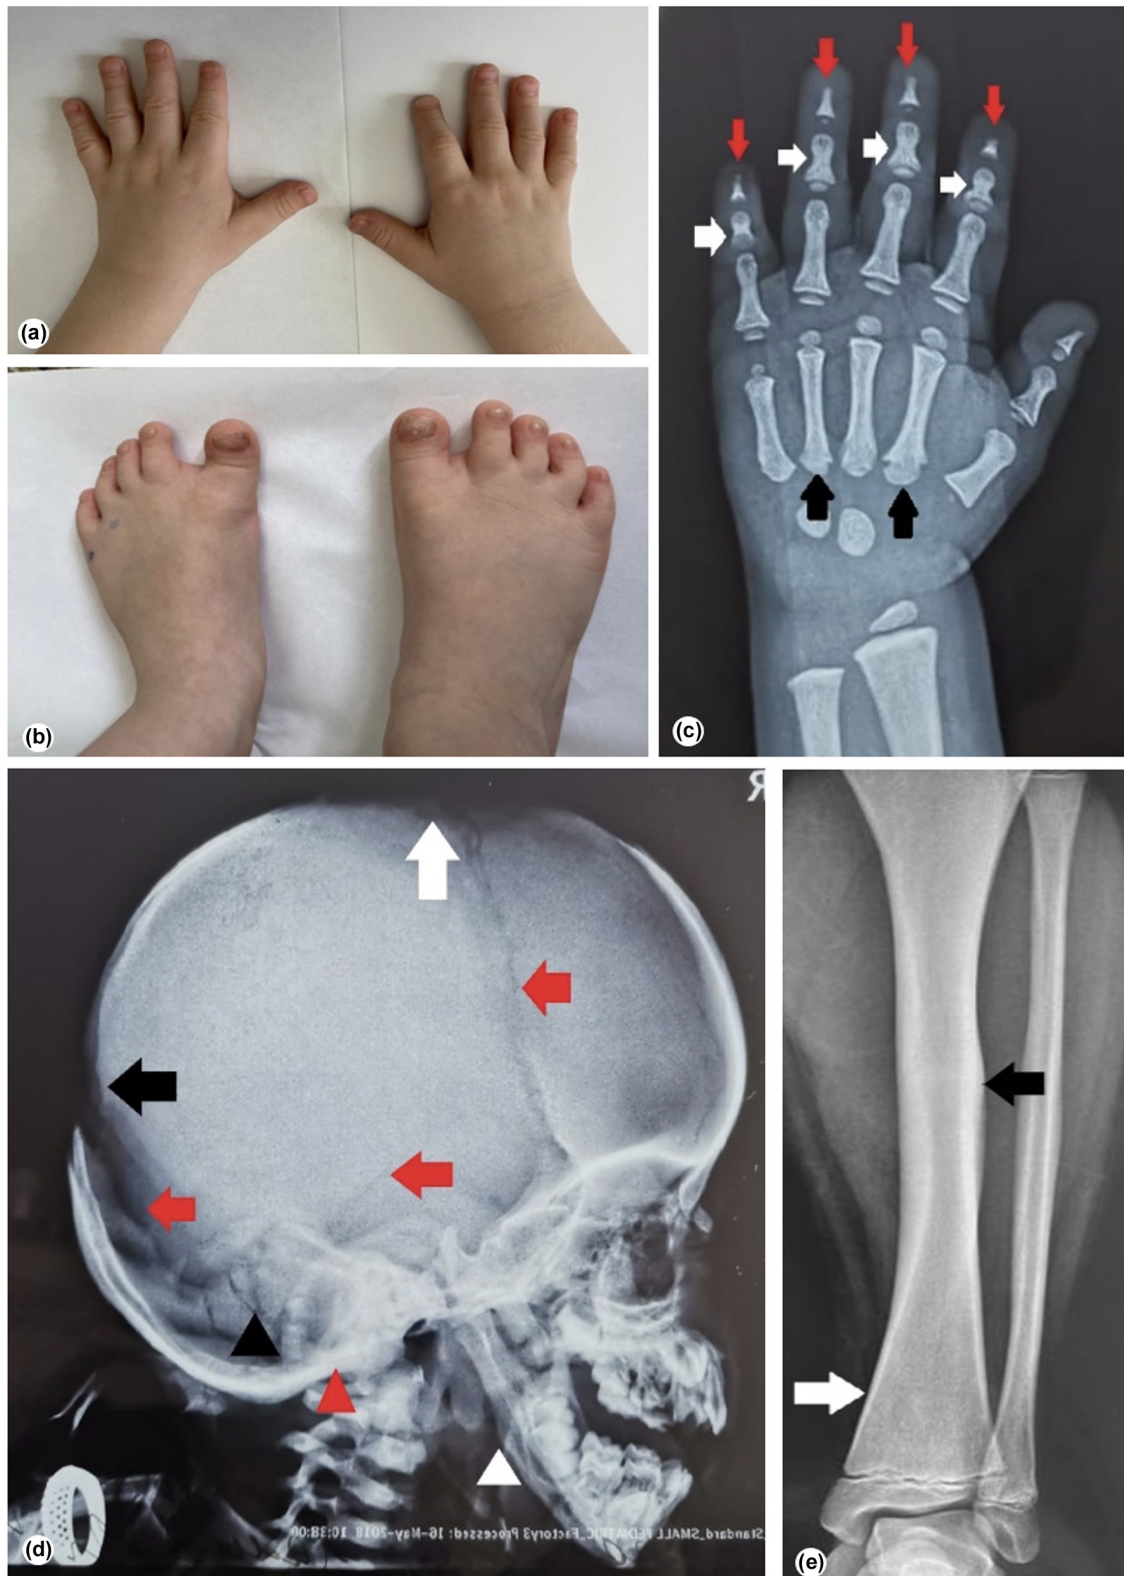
Clinical and radiological features of third patient. (a) Outer appearance of the hands. (b) Outer appearance of the feet. (c) AP radiograph of the hand: Osteolysis of the distal ends of the distal phalanges (red arrows); narrowing of the diaphyses of the middle and basal phalanges (white arrows); pseudoepiphyses of the metacarpals (black arrows). (d) Lateral radiograph of the skull: Opened anterior (white arrow) and posterior (black arrow) fontanelles; opened sutures (red arrows); wormian bones (black arrowhead); dense bones of the skull base (red arrowhead); obtuse mandibular angle (white arrowhead). (e) AP radiograph of the left calf: Undertubulation of the distal metaphysis of the tibia (white arrow); healed fracture of the midshaft of the tibia with cortical thickening (black arrow)
